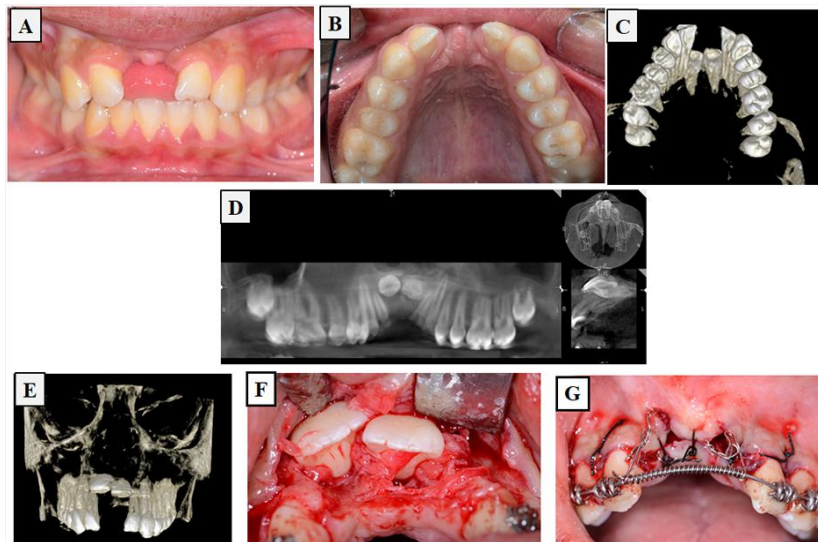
A-G: Trauma-induced developmental displacement and labial impaction of a permanent maxillary anterior tooth following primary incisor trauma: clinical, radiographic, and intraoperative documentation.
